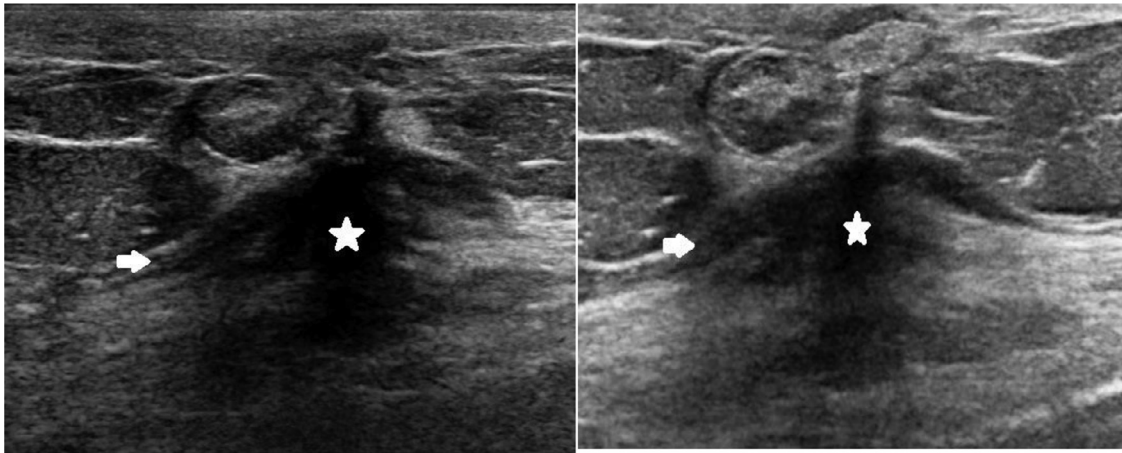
(A, B) Diagnostic ultrasound from September 2020 demonstrates an irregular mass (star) with spiculated margins (arrow) measuring 2.3 x 1.6 x 1.8 cm at 12:00 1 cm from the nipple, corresponding to the patient's palpable finding. Posterior shadowing is also observed.
